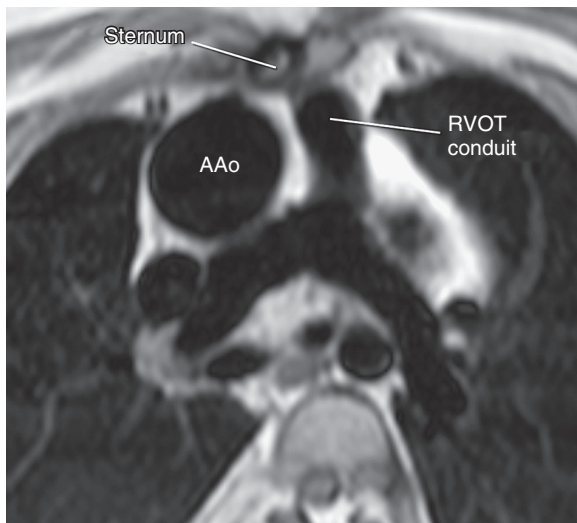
■ Turbo-spin echocardiographic magnetic resonance image in the axial plane demonstrates the ascending aorta (AAo) and right ventricular outflow tract (RVOT) conduit closely adherent to the posterior table of the sternum.
